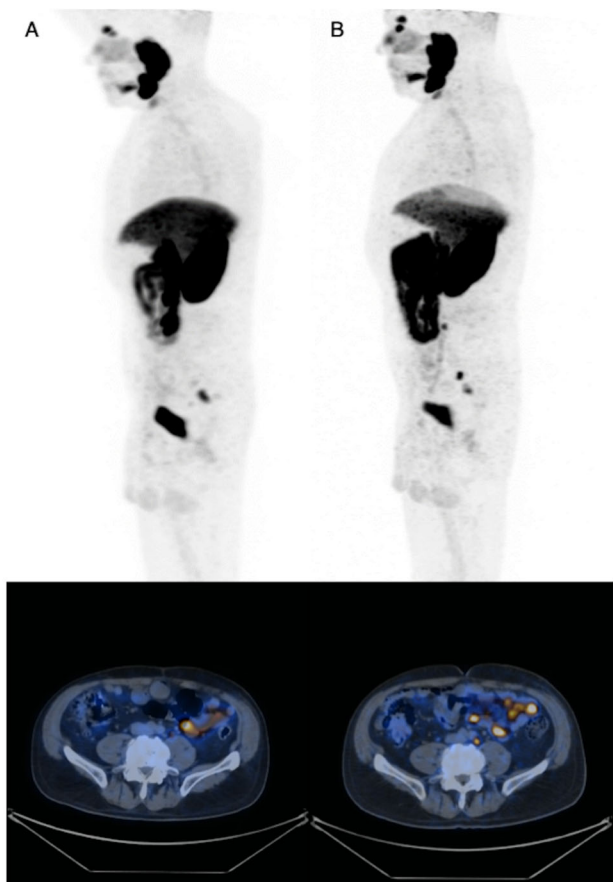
PPP for appearance of only 1 new distant lesion. 67 years old male with history of prostate cancer. S/p radical prostatectomy and adjuvant EBRT in 2003. In 2015 biochemical recurrence, treated with salvage lymphadenectomy and ADT, further increase of PSA with evidence of one nodal lesion at PSMA PET (A). At follow up appearance of a only one new nodal lesion (B). According to PPP in case of only 1 new lesion progression is only confirmed if there is consistent clinical and/or laboratory data and confirmation by biopsy or correlative imaging within 3 months of PSMA PET.
